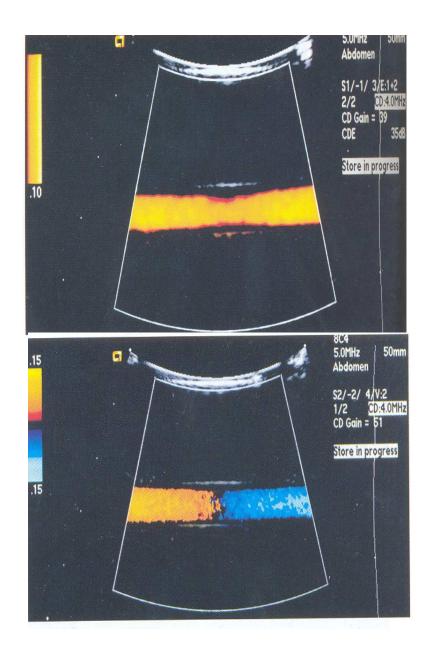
Color flow imaging and power Doppler imaging
